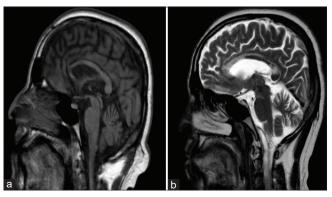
Imaging MRI of the case report (a) Para sagittal T1 W MRI – Thinned out corpus callosum. Linear hypointense areas noted involving the central layers of corpus callosum; (b) T2-SAGITTAL MRI – Hyper intensities noted involving the rostrum, genu, anterior body and splenium of corpus callosum without any mass effect. Source: Author's own work
